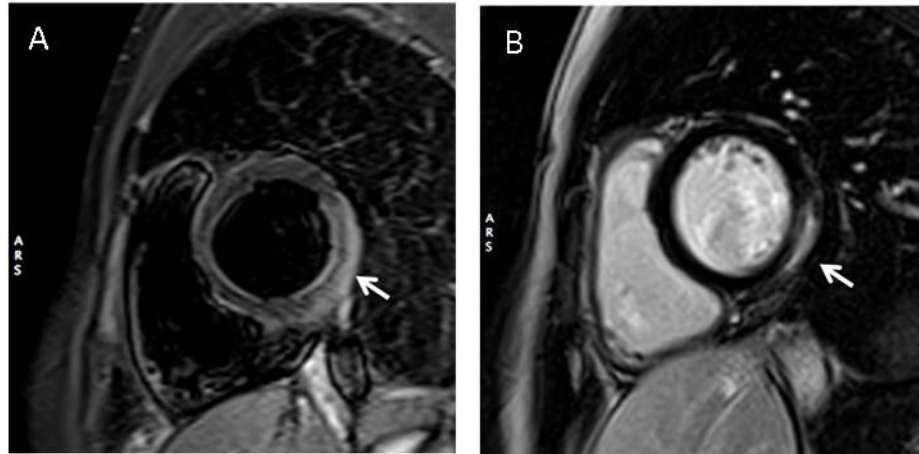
T2-weighted sequence to detect myocardial edema. Note the presence of myocardial edema in the epicardial layer of left ventricle lateral wall (A, white arrow); Delayed post contrast image (LGE) to detect myocardial fibrosis/necrosis. Note the presence of myocardial necrosis in the epicardial layer of left ventricle infero-lateral wall (B, arrow).
